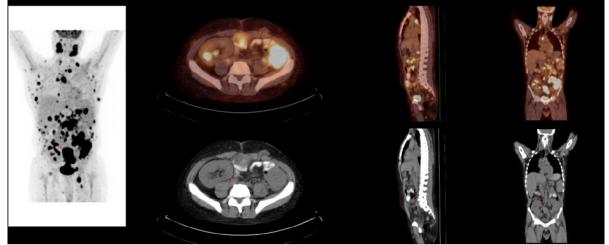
45 years old male status post renal transplant, FDG PET/CT scan showed multiple enlarged highly metabolically active bilateral cervical, mediastinal, axillary, abdominal and pelvic lymph nodes associated with metabolically active right lung nodule, multiple peritoneal, omental and subcutaneous nodules mostly representing active wide spread lymphometous lesions.
